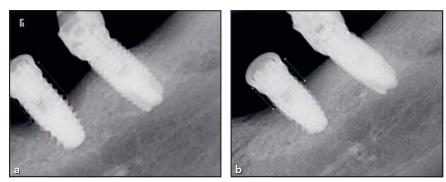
Radiographic measurements of an example case at (a) baseline and (b) 12 months postoperative.
